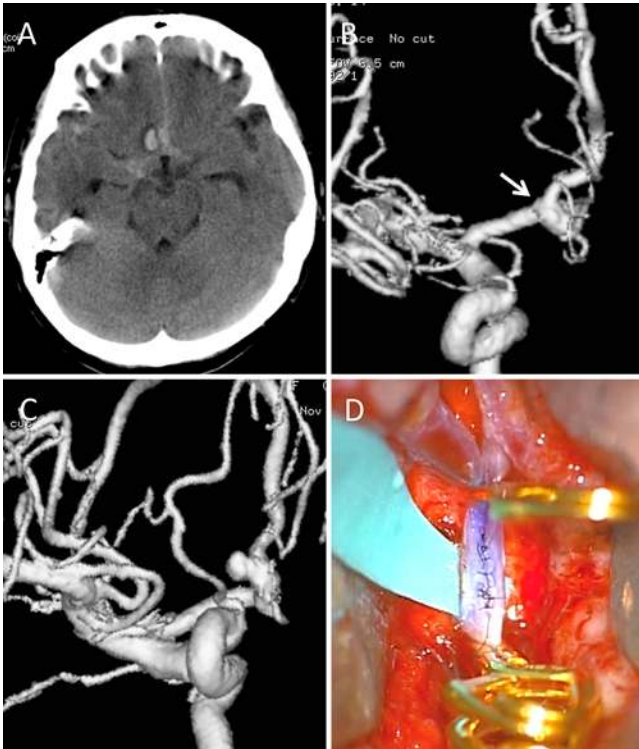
A: Axial CT scan shows a subarachnoid hemorrhage with an intracerebral hematoma in the right rectal gyrus. B: Cerebral angiography shows the small bulge at the right proximal A₂ segment (arrow). C: Follow-up angiography 9 days after the onset shows growth of the aneurysm. D: Intraoperative photograph shows the A₃-A₃ bypass. Figure is available in color online only.
